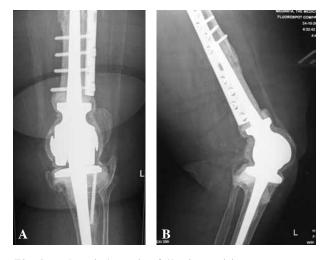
Aseptic loosening following revision surgery : preoperative radiographs. A : AP view ; B : Lateral view.
